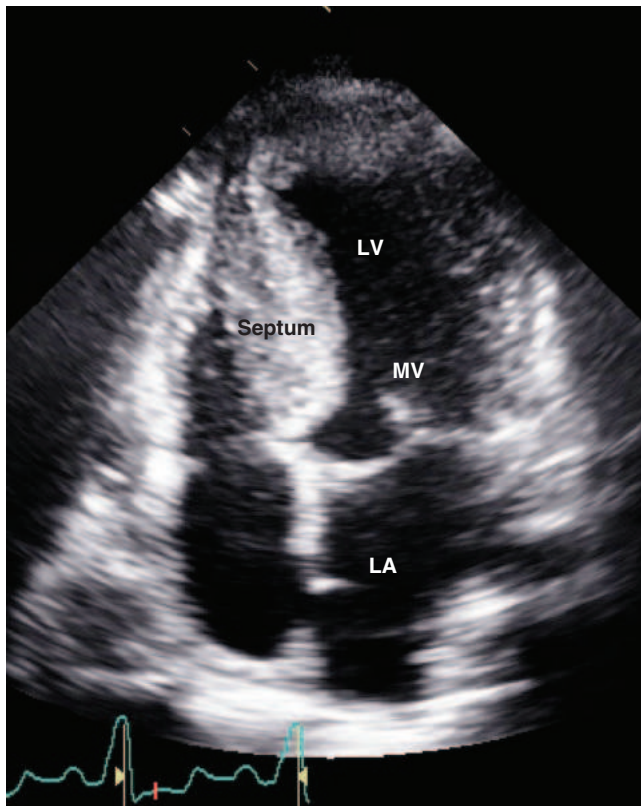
Hypertrophic cardiomyopathy. This echocardiogram of hypertrophic cardiomyopathy shows asymmetric hypertrophy of the septum compared to the lateral wall of the left ventricle (LV). The mitral valve (MV) is moving anteriorly toward the hypertrophied septum in systole. The left atrium (LA) is enlarged. Note that the echocardiographic and pathologic images are vertically opposite, such that the LV is by convention on the top right in the echocardiographic image and bottom right in the pathologic images. (Image courtesy of Justina Wu, MD, Brigham and Women's Hospital, Boston.)
